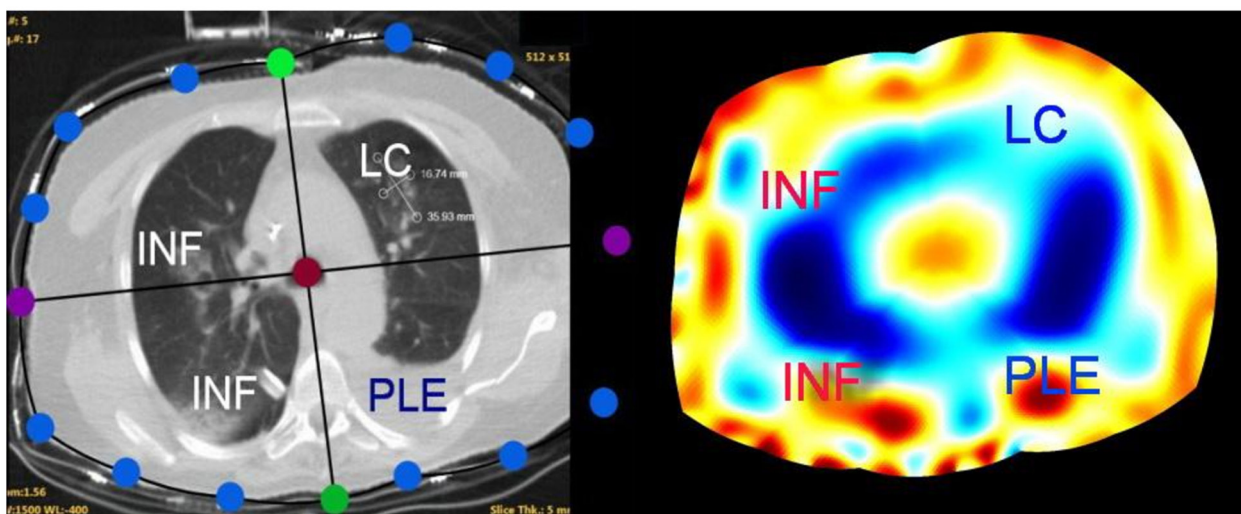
The personalized EIT static image in comparison to the CT scan.
